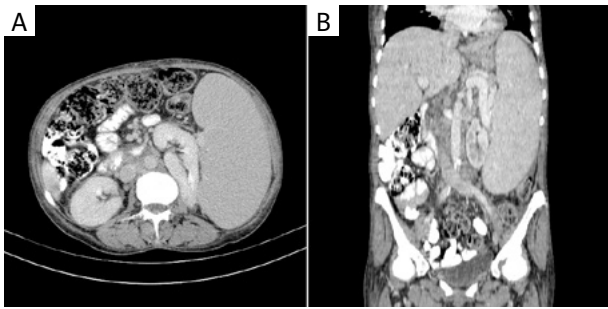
Abdominal CT scan of the patient. Axial (A) and coronal (B) views of the abdomen with huge splenomegaly (270 mm), and hepatomegaly and inguinal lymphadenopathies
